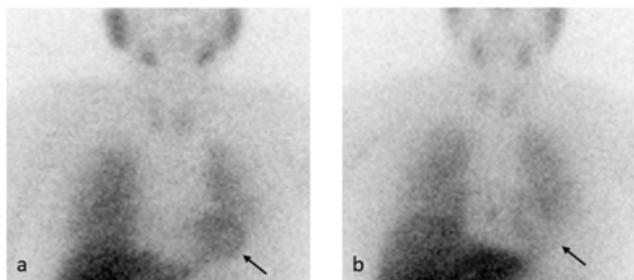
Planar anterior views of ^{123}I -MIBG cardiac scintigraphy showing: a) Normal homogeneous uptake in atypical parkinsonism (progressive supranuclear palsy) and b) Pathologically reduced uptake in PD with dementia (arrows).
